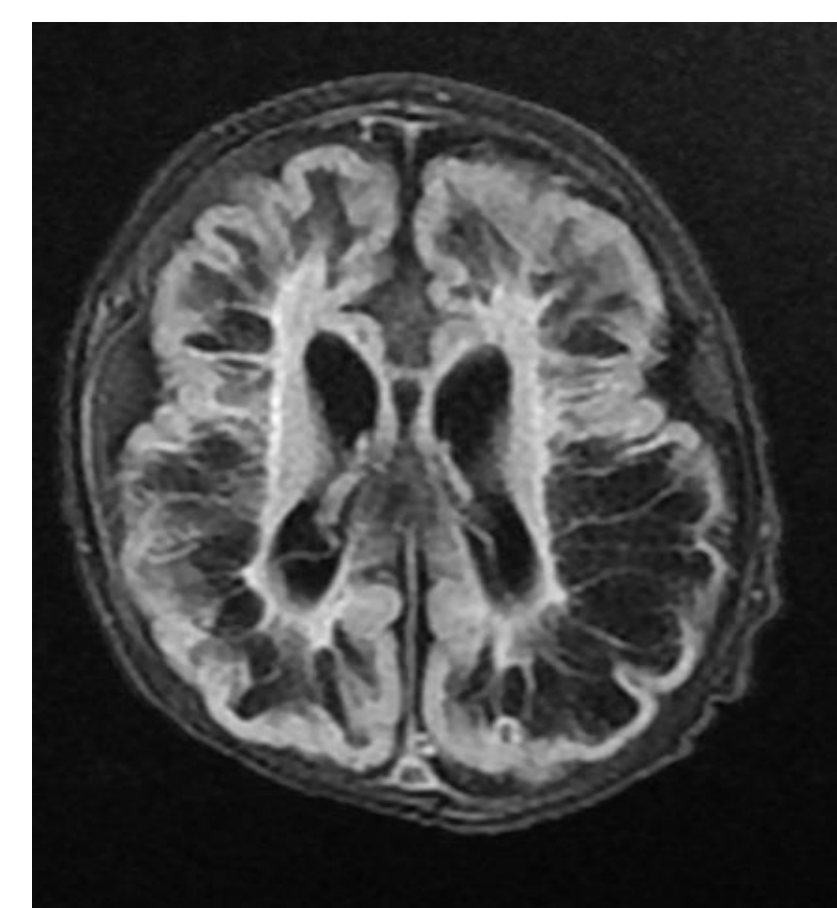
T1 weighted MRI with cystic encephalomalacia in an infant with Molybdenum cofactor deficiency (MOCS1 gene)
